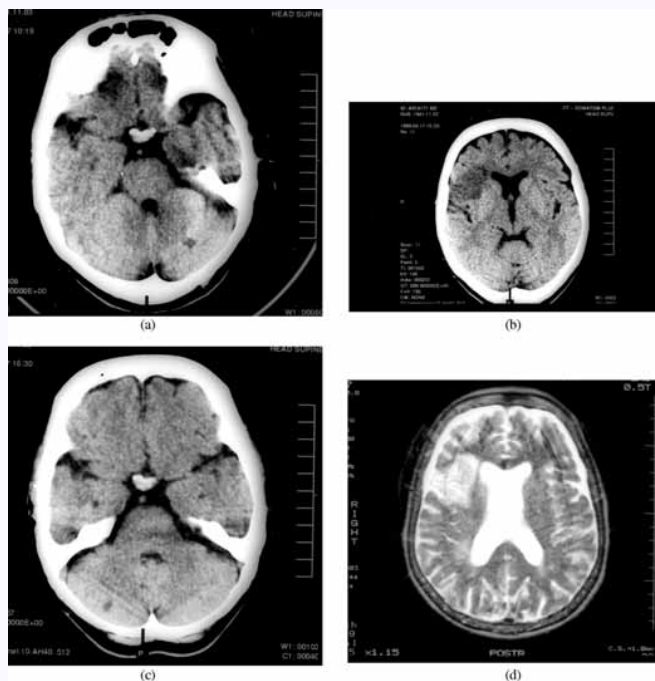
(a) CT brain (without contrast) on Day 1 showing a low-density lesion in the left cerebellar hemisphere. (b) CT brain (without contrast) on Day 10 showing a new low-density lesion in the right posterior frontal region. (c) CT brain (without contrast) on Day 10 showing a new low-density lesion in the right occipital region. (d) MRI brain (without gadolinium enhancement) on Day 26 showing a lesion in the right posterior frontal region.
